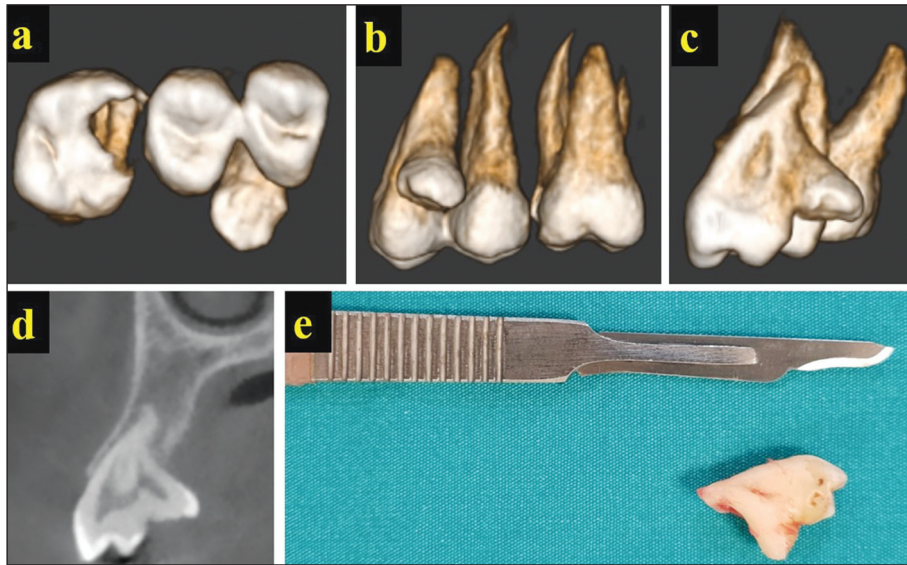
The fusion between the maxillary right first premolar and the supernumerary tooth is shown on three-dimensional reconstruction images [(a) inferior view, (b) palatal view, (c) mesial view], cross-sectional slice (d) of cone-beam computed tomography, and post-surgery photograph (e).
